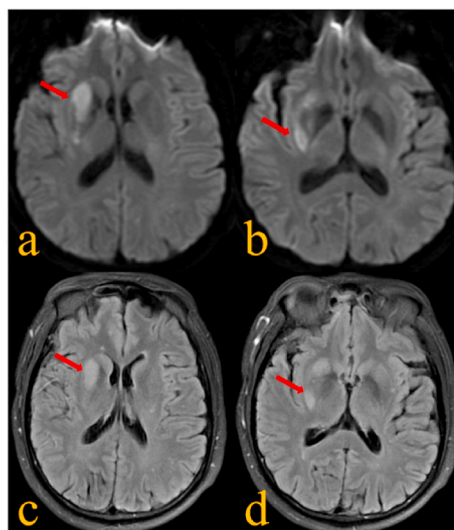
DWI (1a and 1b) and FLAIR (1c and 1d) showed acute cerebral infarction in the right basal ganglia.
